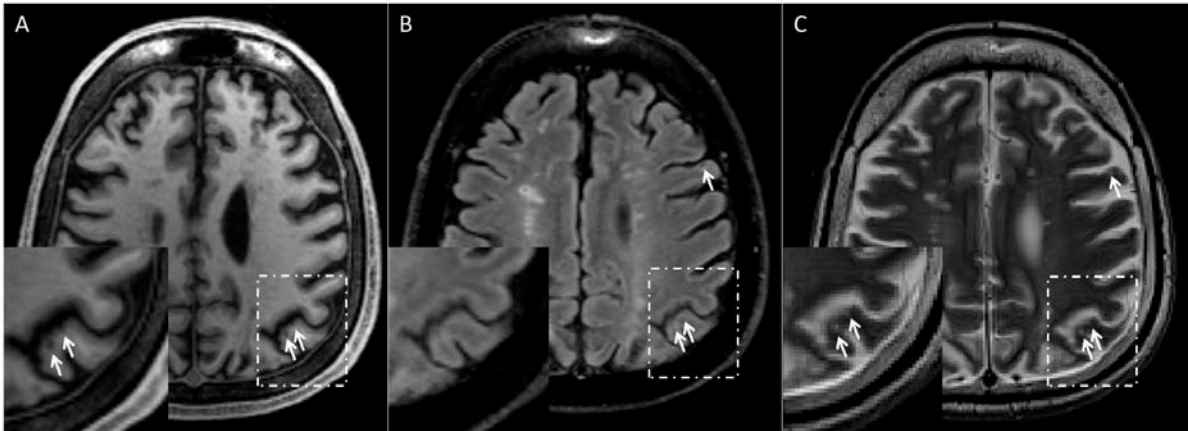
2: Same cortical microinfarct on 7T visible on 3T MRI
